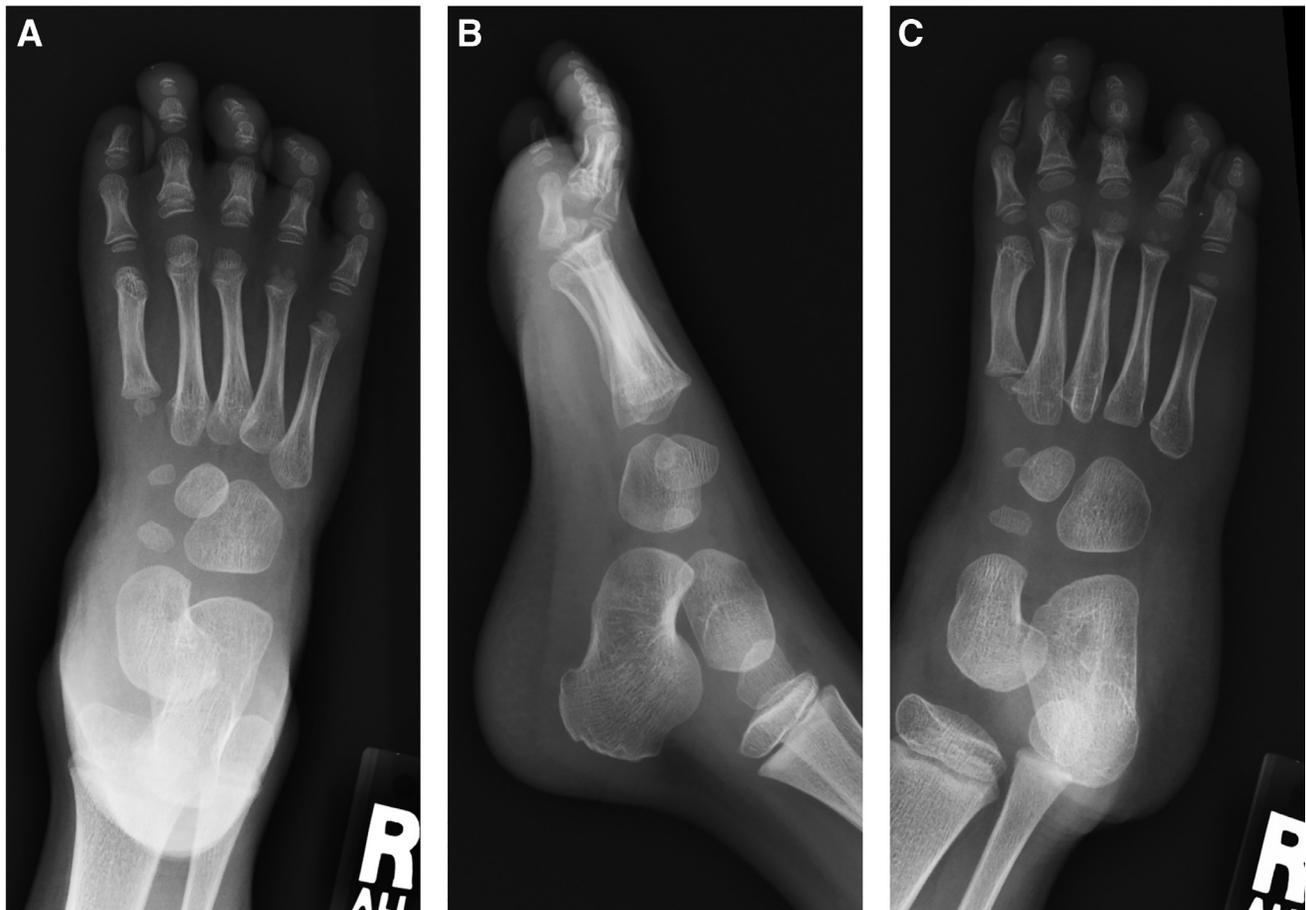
Patient 1, 2-year postoperative radiographs. Anteroposterior (A), lateral (B), and oblique (C) radiographs of the right foot at age 3 years.
